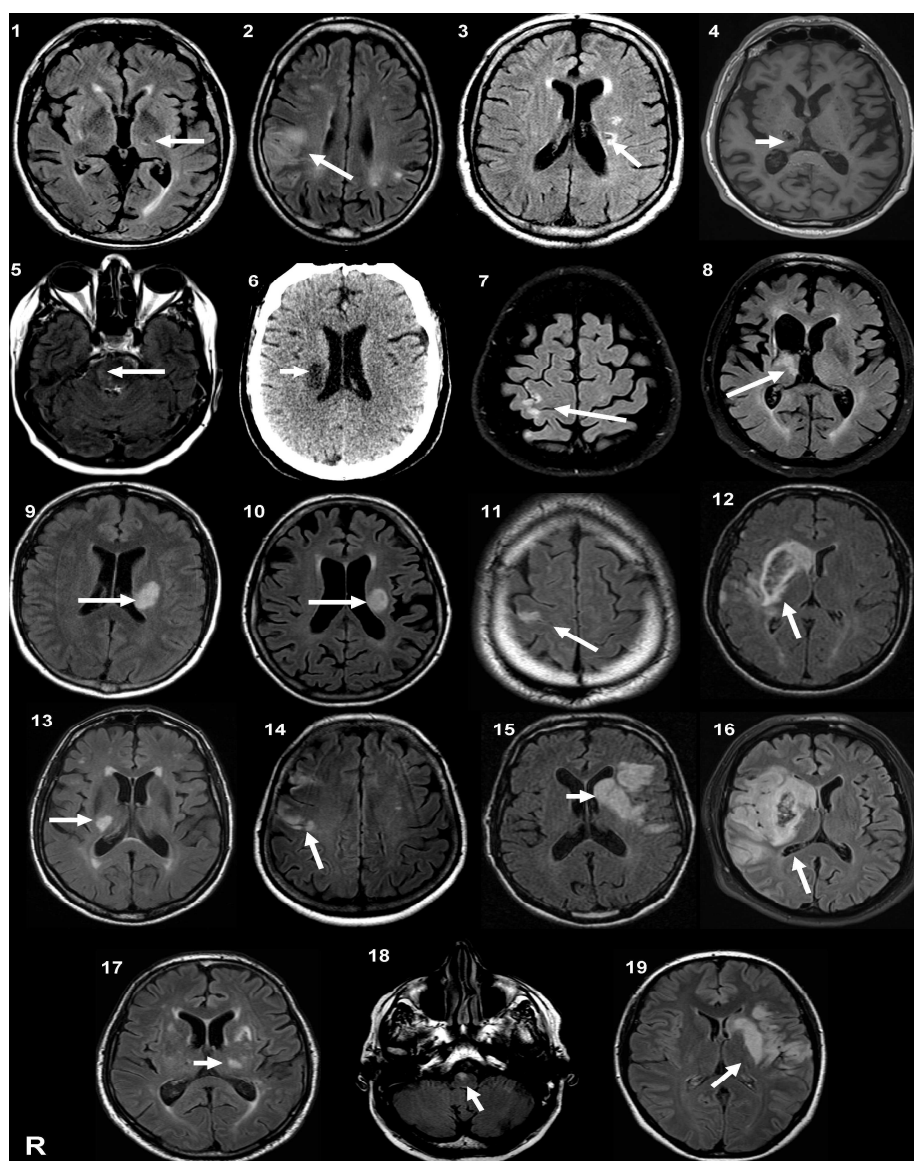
Brain imaging of the stroke patients Magnetic resonance imaging (MRI) or computed tomography (patient 6) at the level of the main stroke injury; T₂-weighted FLAIR except for patient 4 (T₁). Patients 4 and 8 had an intracerebral haemorrhage. There was a slight secondary hemorrhagic transformation in patients 12 and 16. Patients, 2, 14, and 19 had at least one other lesion compatible with a previous, minor stroke. Patients 8, 11, 13, and 17 had associated leukoaraiosis. Patients 1, 2, 11, 13, and 18 had some small chronic subcortical infarcts. Patients 3, 4, and 18 had some small chronic subcortical lacunar infarcts
